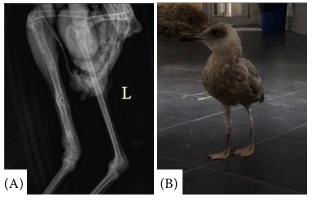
Radiography (A) and feet down image (B) of case 20, post clindamycin therapy and ultrasound therapy
